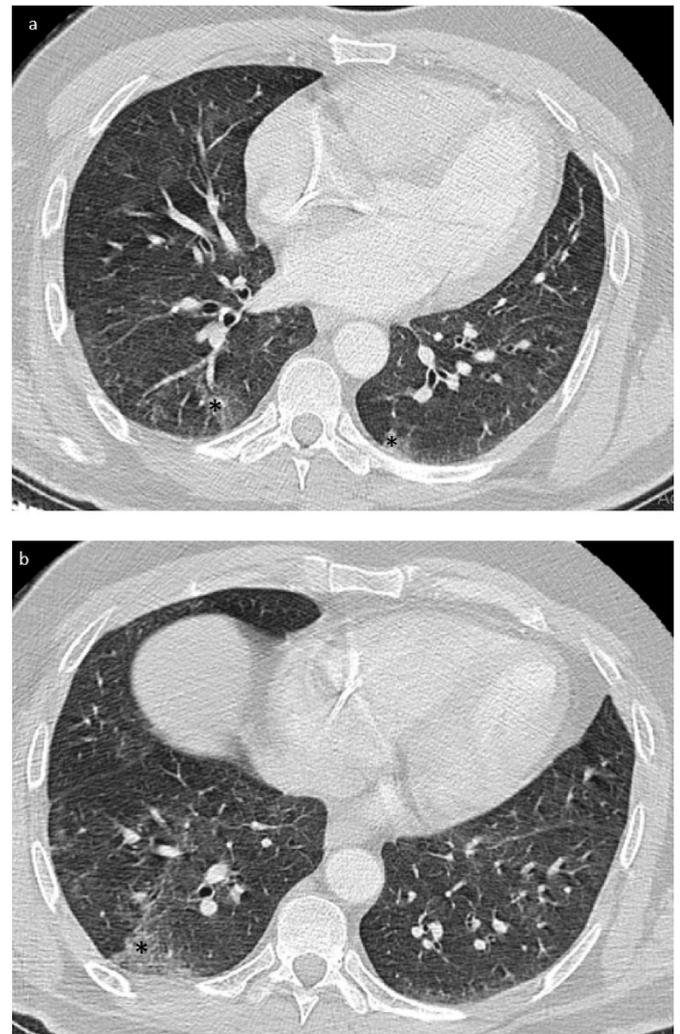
A 42-year-old-man 9 months follow-up axial non-enhanced chest CT images (a,b) showing residual, multi-focal, bilateral, sub-pleural, patchy ground glass opacities (*).
